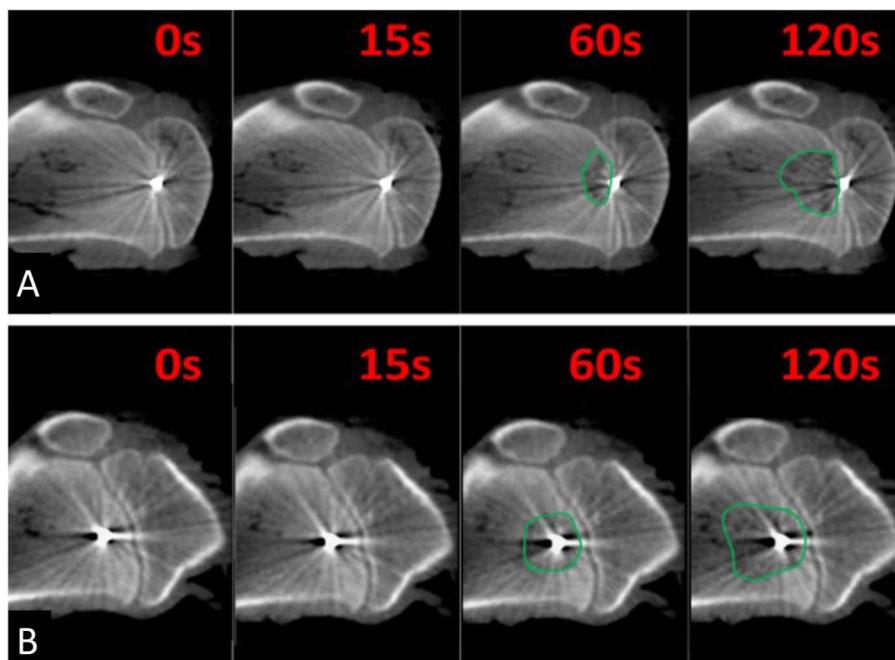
Real-time ablation cone-beam sagittal CT of the (A) intraepiphyseal and (B) metaphyseal configurations demonstrates heat and visible gas formation (outlined in green). Red text denotes ablation times. Note the protective nature of the growth plate and general deflection of heat away from the articular cartilage.
